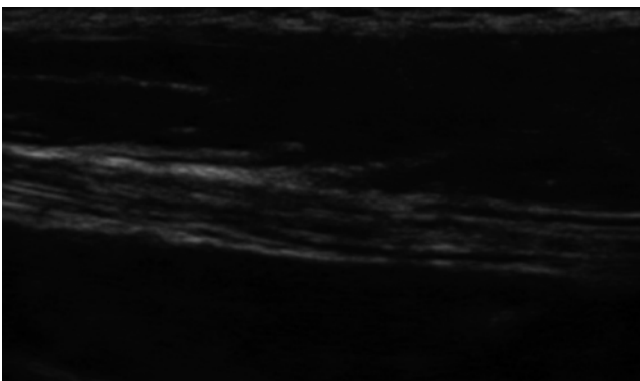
Longitudinal (*long axis*) ultrasound image (Image courtesy of Andrea Trescot, MD)
